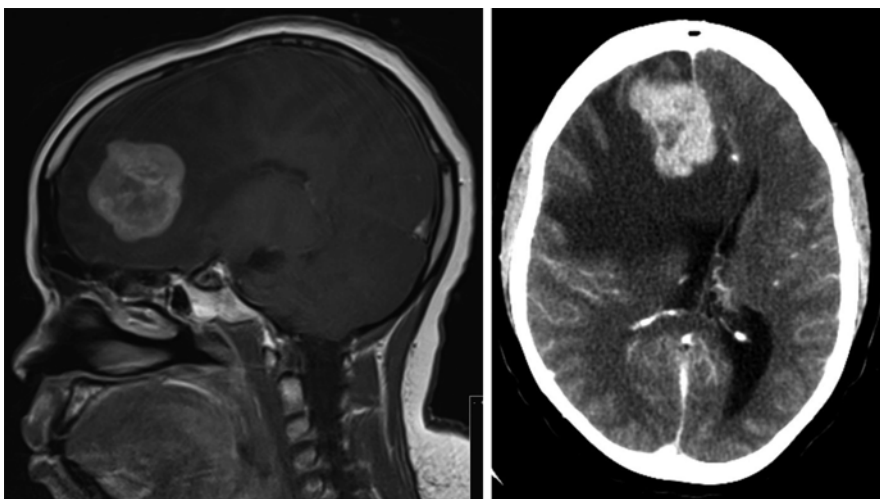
MRI scan showing frontal PCNSL in a person living with HIV (PLWH)
